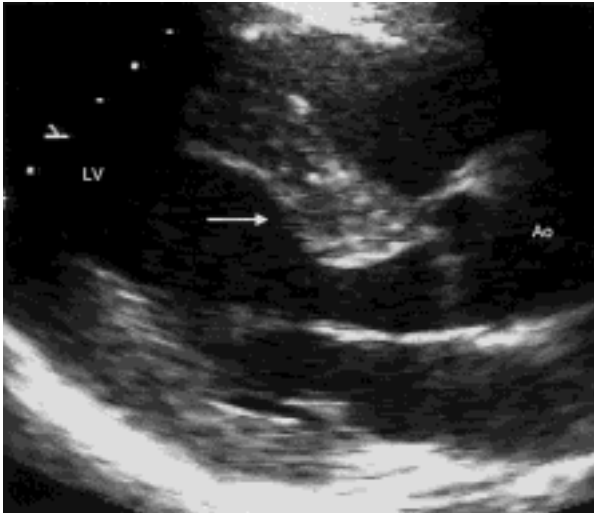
Upper septal bulge (arrow). Parasternal long-axis view.
